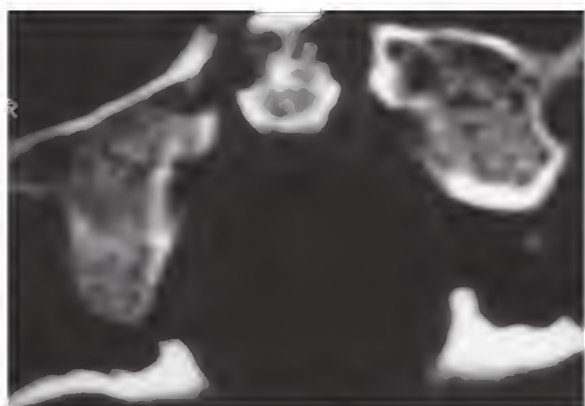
Myeloma detected on a computed tomography scan of a 63-year-old man with known multiple myeloma in whom neck pain developed. Plain radiographs and a bone scan failed to demonstrate the osteolytic lesions affecting the odontoid peg.
